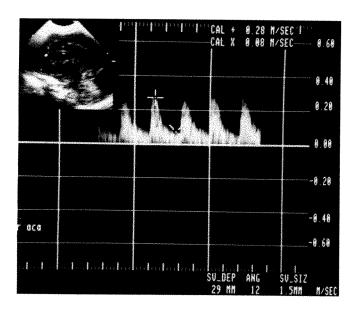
Duplex study of anterior cerebral artery. Doppler angle is 12°. Anterior fontanelle is used to insonate this vessel.
